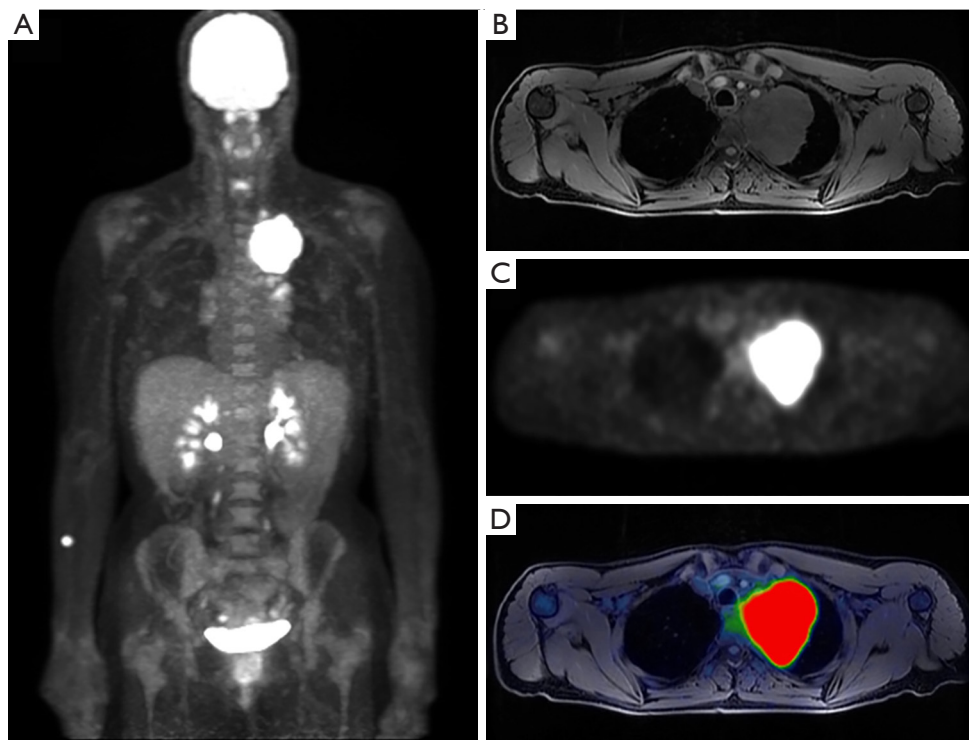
A 44-year-old female presenting with 30 lb weight loss and sharp upper left chest pain found to have a left upper lobes mass on chest radiograph (not shown). Staging FDG PET/MR without IV contrast was performed. MIP reconstruction (A) demonstrates an FDG avid Pancoast tumor with additional FDG avid left cervical and hilar lymph nodes. T1 weighted image with fat saturation (B), axial PET (C) and fused (D) images further delineate degree of mediastinal invasion.
